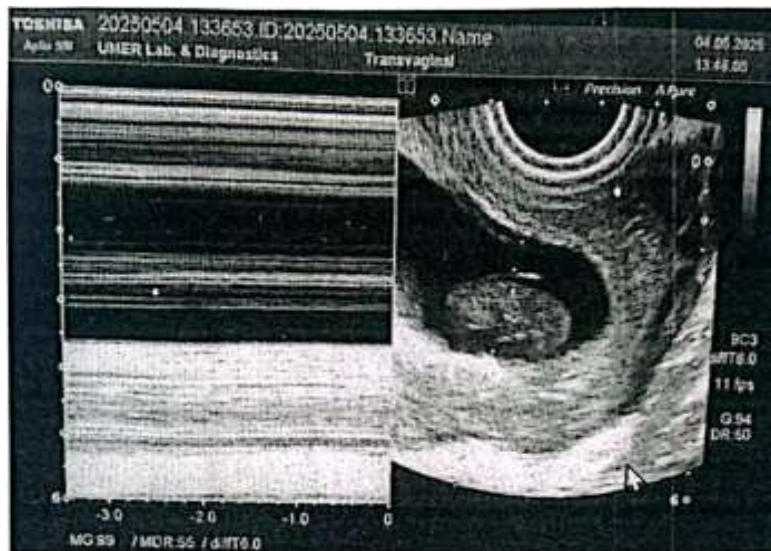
Transabdominal ultrasound scan showing an increase heartrate (Tachycardia). The mode image (right) displays a gestational sac with a fetal pole, while the M-mode trace (left) confirms fetal cardiac activity with a heart rate of 169 bpm. Scan performed on 12 June 2025 asing Toshiba Aplio 500 at UMER Lab & Diagnostics.
